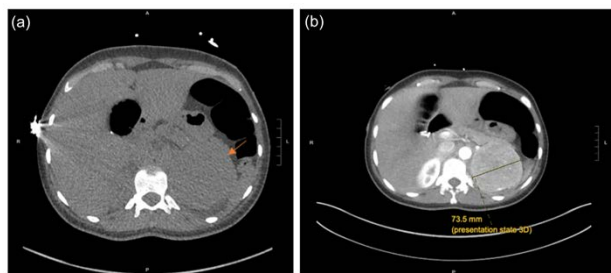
(a) Patient's CTA showing a mass in the upper left quadrant of her abdomen. (b) Patient's subsequent contrast-enhanced abdominal CT showing the adrenal mass
